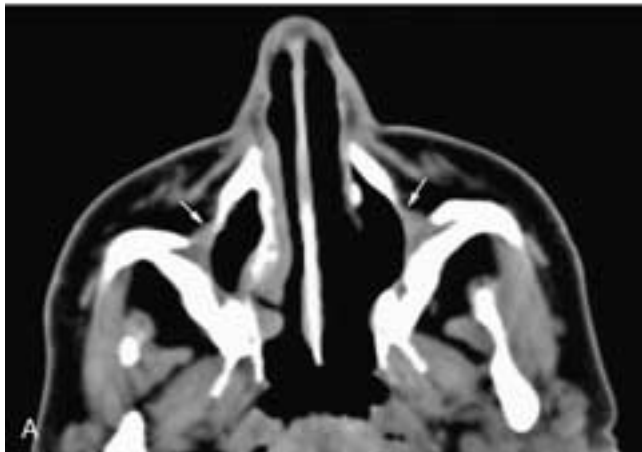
Axial CT scans seen at narrow (A) and wide (B) window settings on a patient after bilateral Caldwell-Luc procedures. The thickening of the posterolateral sinus bony walls is a reaction to the denuding of the sinus mucosa during the procedure and is an expected postoperative finding. Note the fibrous tissue that closes off the anterior sinus wall defect (*arrows* in A).
